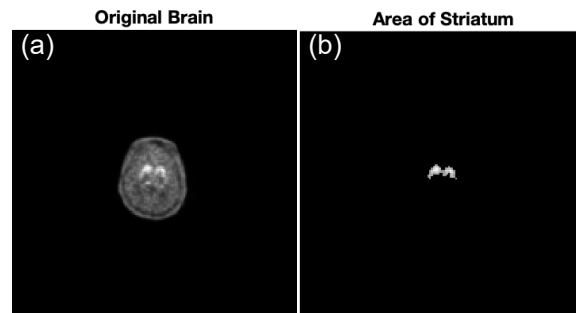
Image segmentation of patient No.1 by using Otsu’s Algorithm with gray scale. (a) Original PET/CT imaging and (b) image segmentation of striatum.
